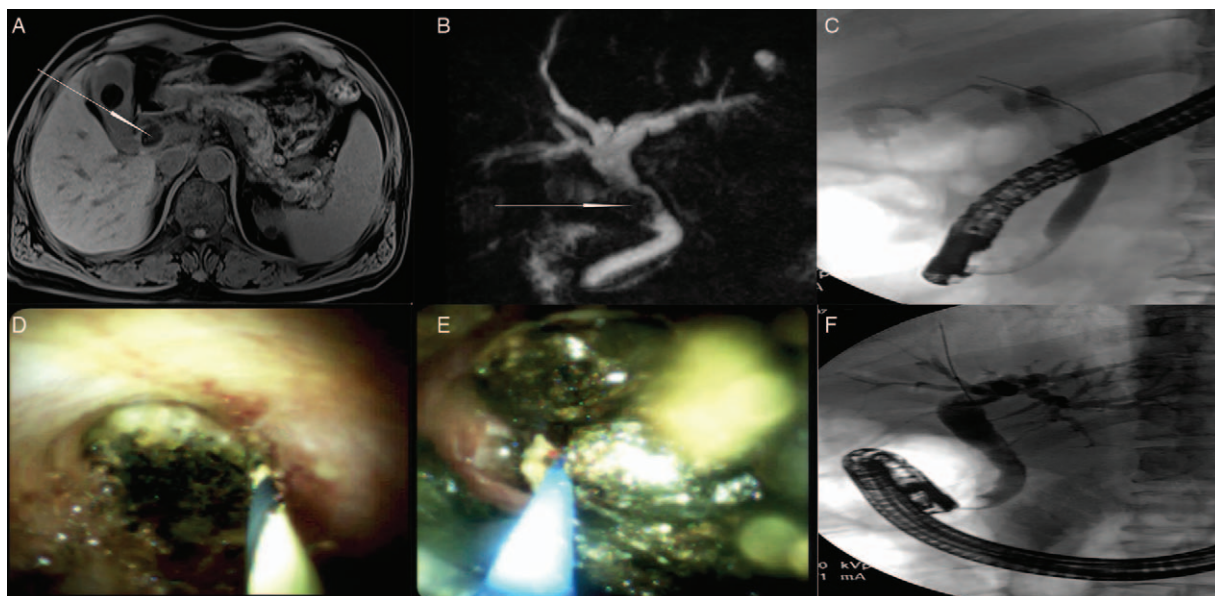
Imaging features before and after the endoscopic retrograde cholangiopancreatography. (A) T1-weighted axial image with fat suppression demonstrated a low signal intensity gallstone (white arrow) in the cystic duct. (B) Magnetic resonance cholangiopancreatography showed a low signal intensity gallstone (white arrow) impacted in the cystic duct and the common bile duct. (C) Intraoperative cholangiography showed a filling defect of 20 mm × 12 mm at the upper common bile duct, with contrast agent filling the gallbladder but not the intrahepatic bile duct. (D) Spyglass showed impacted cystic duct stone. (E) Laser lithotripsy under direct view of Spyglass. (F) Balloon occluded cholangiography showed that intrahepatic bile duct was filled with contrast agent and the previous filling defect had disappeared.
